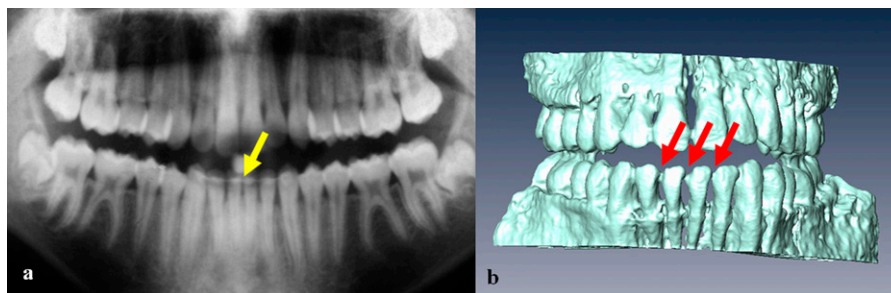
Panoramic radiograph image (a) and a three-dimensional MRI reconstruction (b) of the teeth of a volunteer with an NiTi retainer (arrows)
